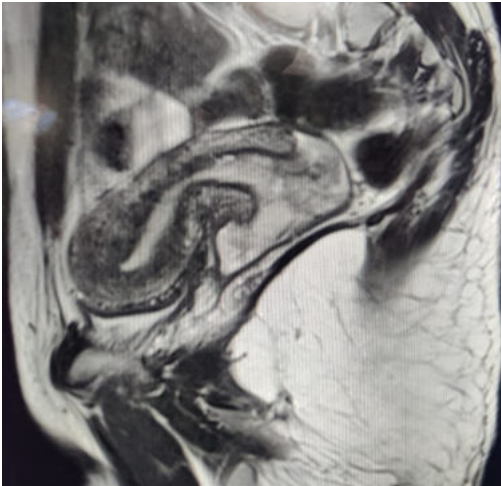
MRI image showing the lesion arising from cervix; rest of the pelvis is unremarkable.
